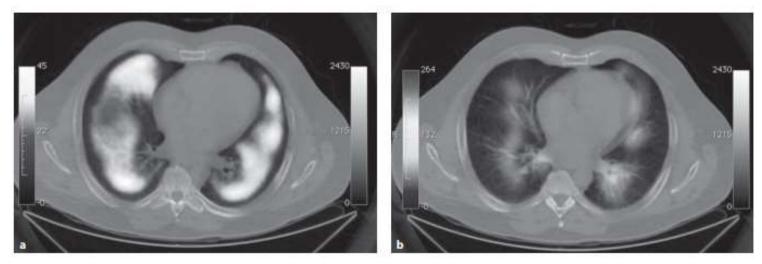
a SPECT/CT fusion Technegas imaging of an asthmatic patient at baseline. Ventilation is mildly heterogeneous. The lack of apparent ventilation to the lung periphery is likely due to insufficient resolution to detect low ventilation. b Ventilation imaging postmethacholine challenge when FEV₁ was reduced by approximately 20%. Note the reduction in ventilated volume and more heterogeneous distribution, which is based on small airway function.
